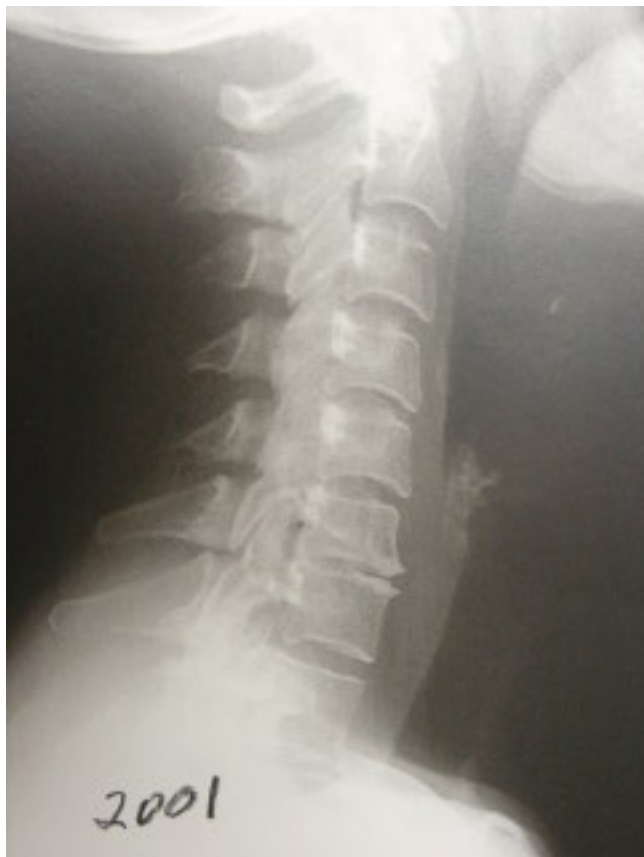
note the degenerative changes at the C6-7 disc level with the loss of physiological sagittal curve and flexion subluxation of C3 on C4. Note the normal appearance of the cephalad and caudad discs to C6-7, especially the C4-5 level. This x-ray was taken in 2001.
